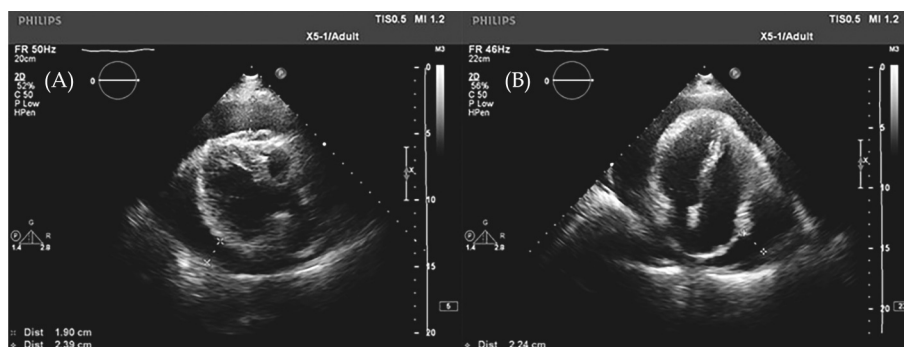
Echocardiography images two years ago. (A): Transthoracic echocardiography showed pericardial effusion in long-axis view; (B): transthoracic echocardiography apical four-chamber view demonstrated pericardial effusion.
